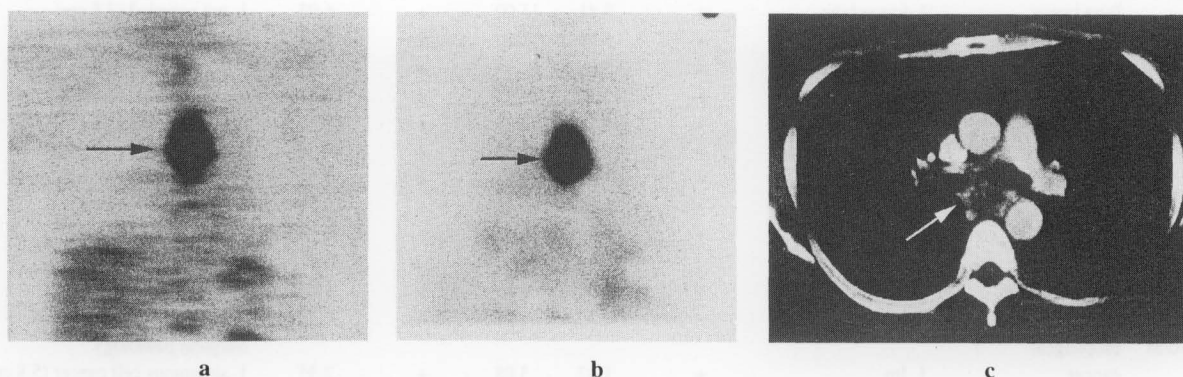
A case of esophageal cancer. Both the coronal section of the FDG image obtained with the dedicated PET camera (a) and that obtained with the dual-head coincidence gamma camera (b) revealed the primary lesion (arrow) showing on the CT image (c).
